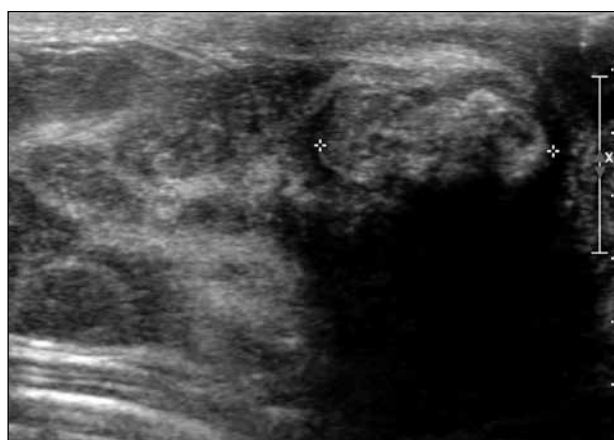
Ultrasonogram of the left breast of a 33-year-old lactating woman showing a hyperechoic circumscribed oval lesion with posterior shadowing at the subareolar region. Echogenicity is likely from milk component as abscess is less likely to be echogenic. Yellowish fluid was yielded on fine needle aspiration, pathologically confirmed to be inflammatory exudate, in keeping with a breast abscess.
